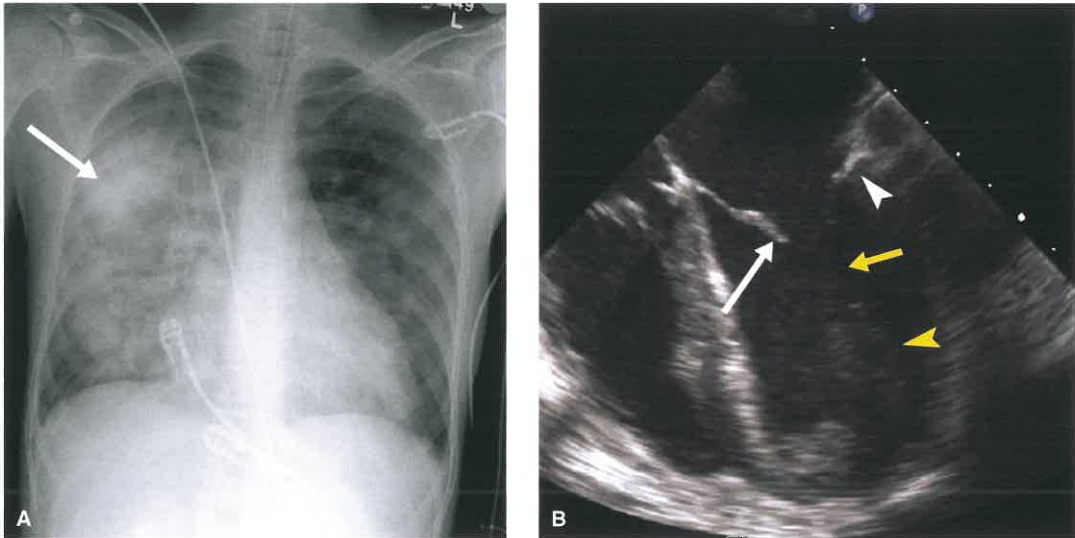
A: AP radiograph in a 49-year-old woman with severely worsening dyspnea 7 days after RCA territory infarct shows asymmetric edema most notably in the right upper lung (*white arrow*). B: Four-chamber view from a bedside echocardiogram shows a flail posterior leaflet (*white arrow*) leading to severe acute mitral regurgitation. The anterior leaflet (*white arrow*) is still attached to its chordae (*yellow arrow*) and papillary muscle (*yellow arrowhead*). The rightward and superior direction of the jet causes this characteristic finding. The patient underwent emergent surgery to repair the valve.
